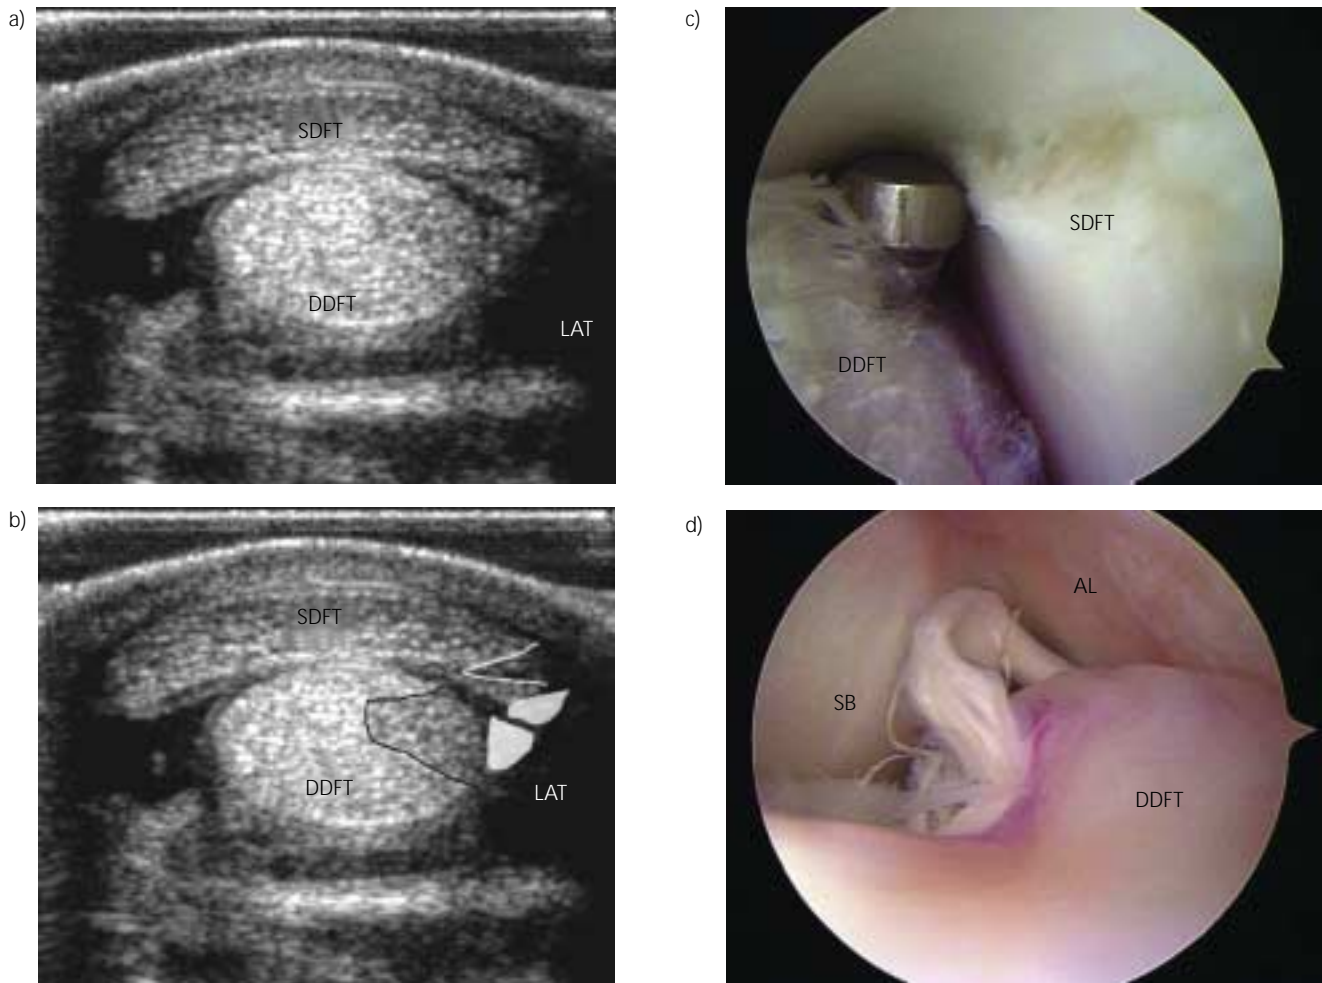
a) Transverse, midline ultrasonographic image approximately 18 cm distal to the base of the accessory carpal bone; note the lack of definition in the lateral edge of the superficial digital flexor tendon (SDFT), the presence of echogenic tissue lateral (LAT) to the deep digital flexor tendon (DDFT) and decreased echogenicity in the lateral third of the DDFT. b) The same image as (a) with the noted pathology highlighted. c) The areas outlined in both the SDFT and DDFT were found at tenoscopy to represent longitudinal tears in the SDFT and DDFT. d) The solid white areas lateral to the tendons, depicted in (a) and (b), corresponded to frayed tendon edges. AL = Annular ligament; SB = sesamoid bone.
